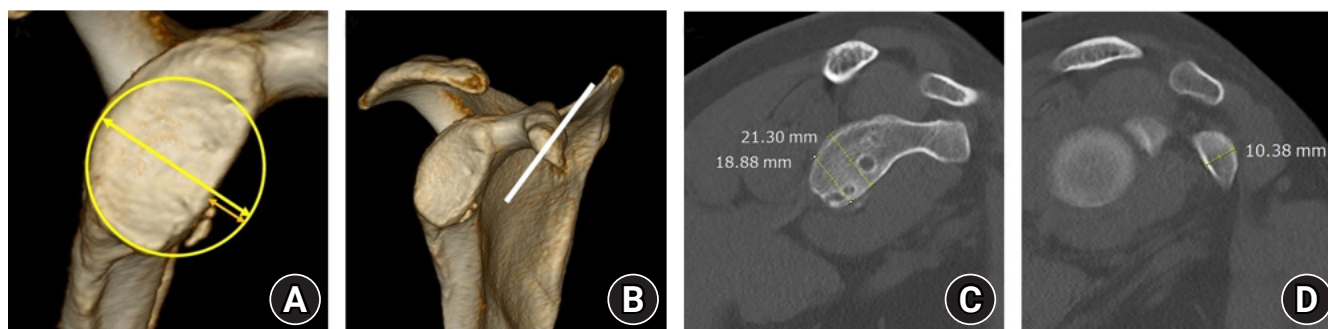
Checklists with preoperative three-dimensional computed tomography right shoulder. (A) Glenoid bone defect is assessed on enface view using Sugaya method. (B) The approximate screw angle and location should be determined by analyzing the direction and inclination of the coracoid process. (C) The anteroposterior length of glenoid is checked. (D) The anteroposterior thickness of the coracoid process is assessed. Taken together with the anteroposterior glenoid size, this thickness estimates the approximate length of the screw.
